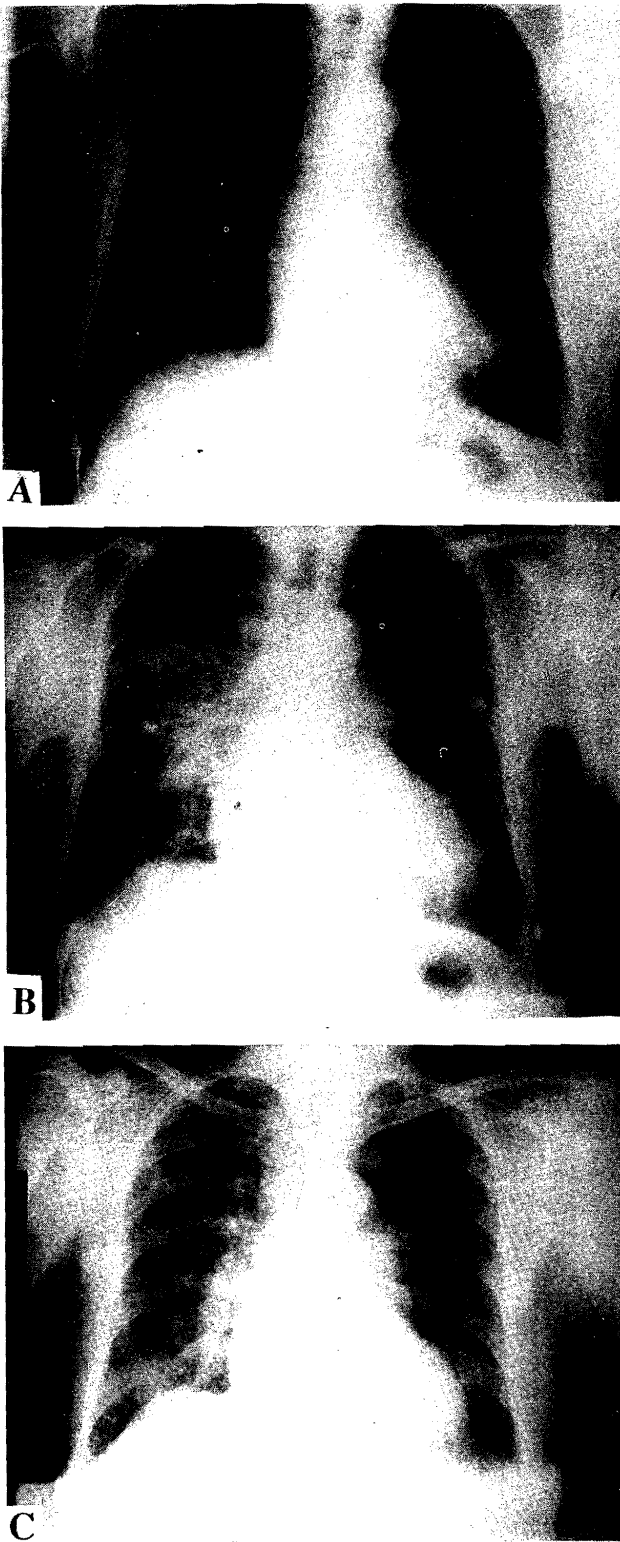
Chest X-rays before (A), during (B), and after (C) discontinuation of interferon therapy.
